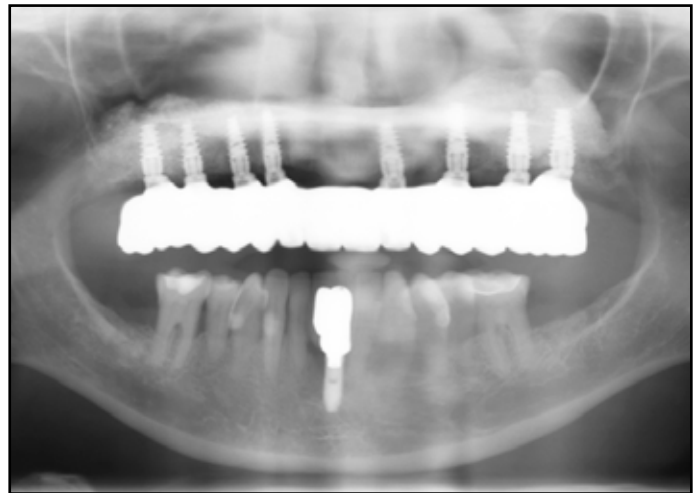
Radiograph of dental implants and final restoration immediately after initial delivery.
